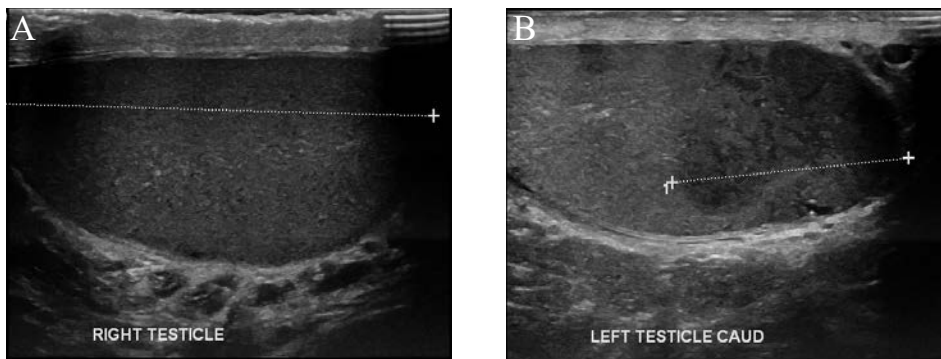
Ultrasound; A, normal testis; B, testis with confirmed DLBCL infiltration (markings)
